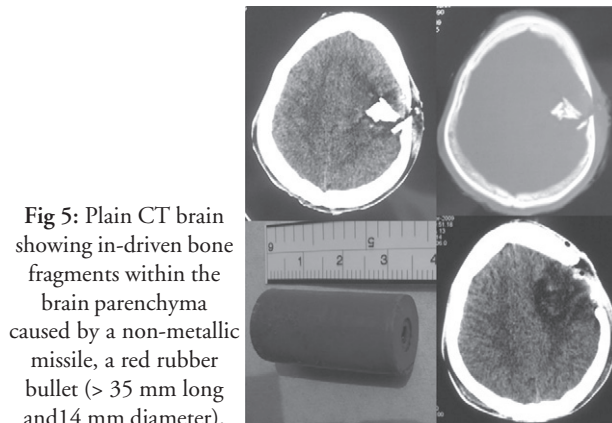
Plain CT brain showing in-driven bone fragments within the brain parenchyma caused by a non-metallic missile, a red rubber bullet (> 35 mm long and 14 mm diameter).
